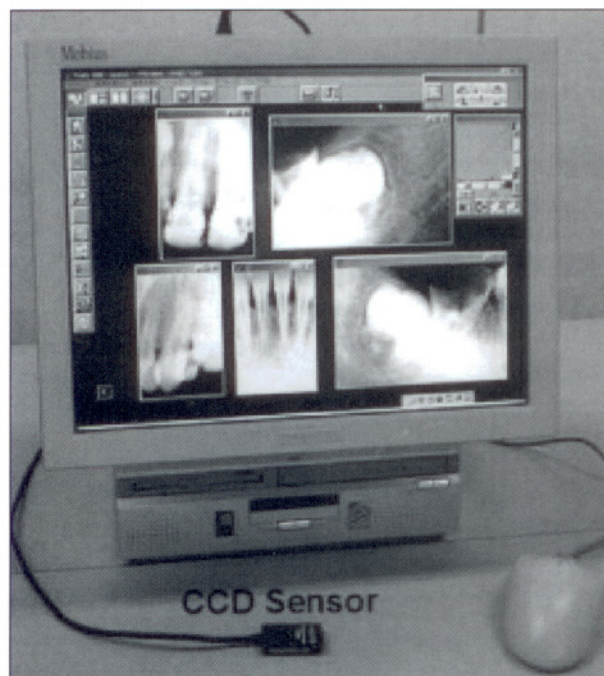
The direct digital X-ray system (Compuray). A number of images are displayed at the same time
